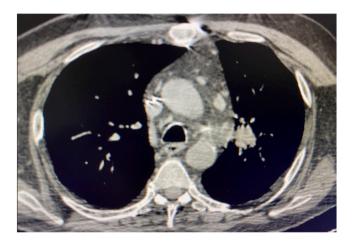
CT scan of the chest on admission, demonstrating an abnormal airspace density in the left suprahilar region, concerning for either inflammatory or neoplastic etiology. The lesion is occult on plain chest radiograph.
